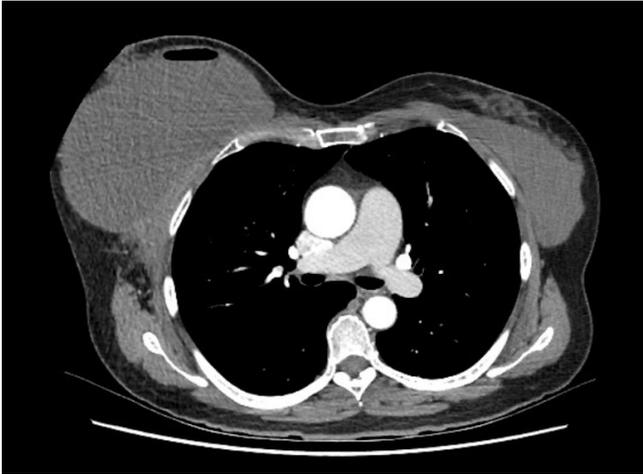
Right breast collection seen on CT
